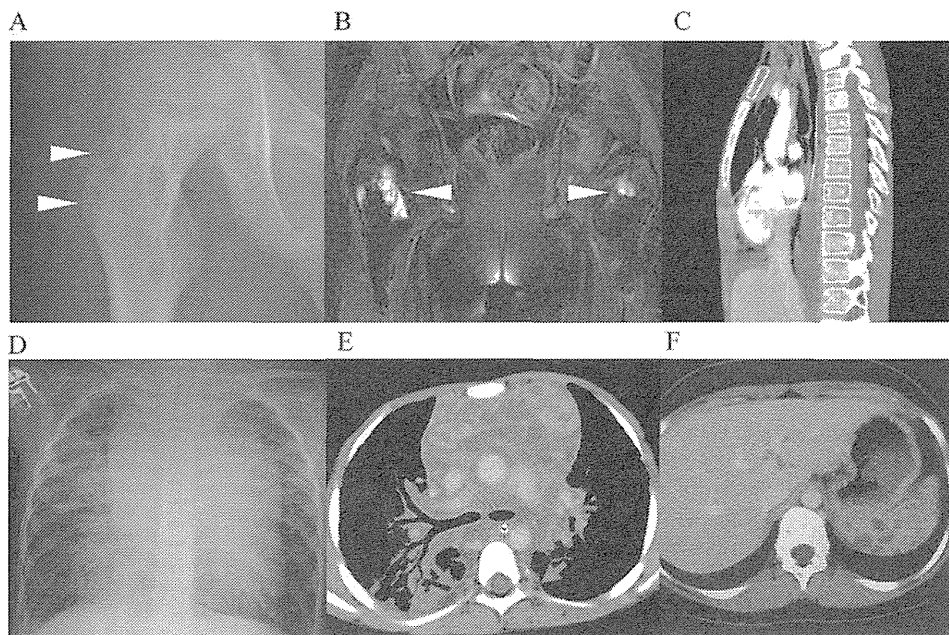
Radiological findings of patients with GLA and KLA. (A–C and F) Twelve-year-old male with GLA involving bone and spleen. (A) Plain radiography of femoral head shows a small lytic lesion (white arrowheads). (B) Coronal fat suppressed, T2-weighted MRI of femoral head shows a small lytic lesion (white arrowheads). (C) Contrast-enhanced CT of the chest with sagittal reconstruction shows dissemination of osteolysis in the vertebrae. (D and E) Eight-year-old male with KLA involving the thoracic region. (D) Chest radiography shows pronounced effusion, mediastinal enlargement, and peribronchovascular infiltration extending from the hilar to the peripheral area. (E) Chest contrast-enhanced CT demonstrates diffuse thickening of the interlobular septa, pleural effusion in the right lung, and retroperitoneal soft tissue mass (red arrows). (F) An axial projection shows multiple cystic lesions in the spleen. CT, computed tomography; GLA, generalized lymphatic anomaly; KLA, kaposiform lymphangiomatosis; MRI, magnetic resonance imaging.
